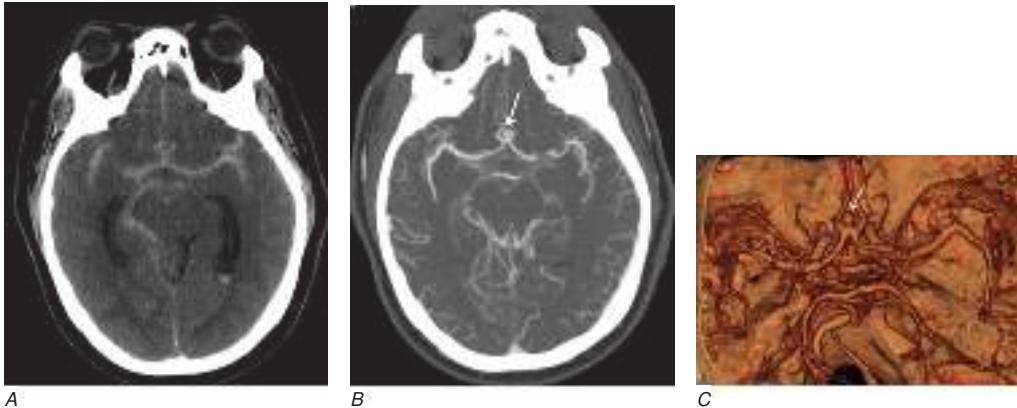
Computed tomography (CT) angiography (CTA) of ruptured anterior cerebral artery aneurysm in a patient presenting with acute headache. *A*, Noncontrast CT demonstrates subarachnoid and intraventricular hemorrhage and mild obstructive hydrocephalus. *B*, Axial maximum-intensity projection from CTA demonstrates enlargement of the anterior cerebral artery (arrow). *C*, Three-dimensional surface reconstruction using a workstation confirms the anterior cerebral aneurysm and demonstrates its orientation and relationship to nearby vessels (arrow). CTA image is produced by 0.5- to 1-mm helical CT scans performed during a rapid bolus infusion of IV contrast medium.
